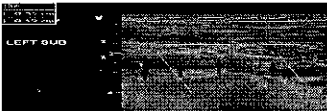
Ultrasound disclosed thrombus over left subclavian vein.
